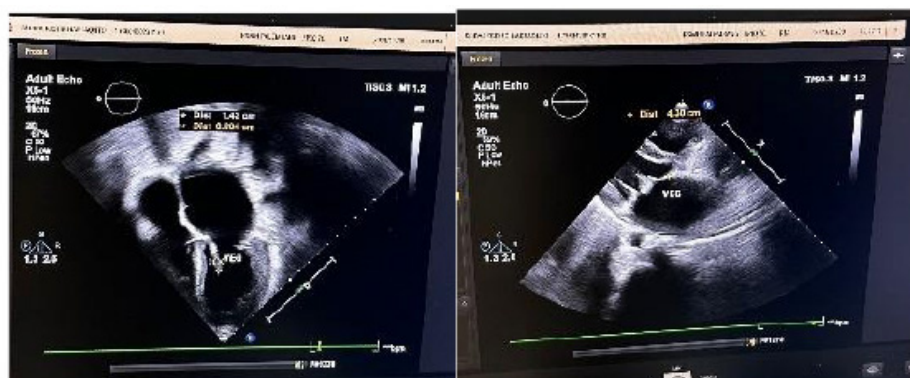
Echocardiography showed vegetation and tear in the mitral valve and severe mitral regurgitation
